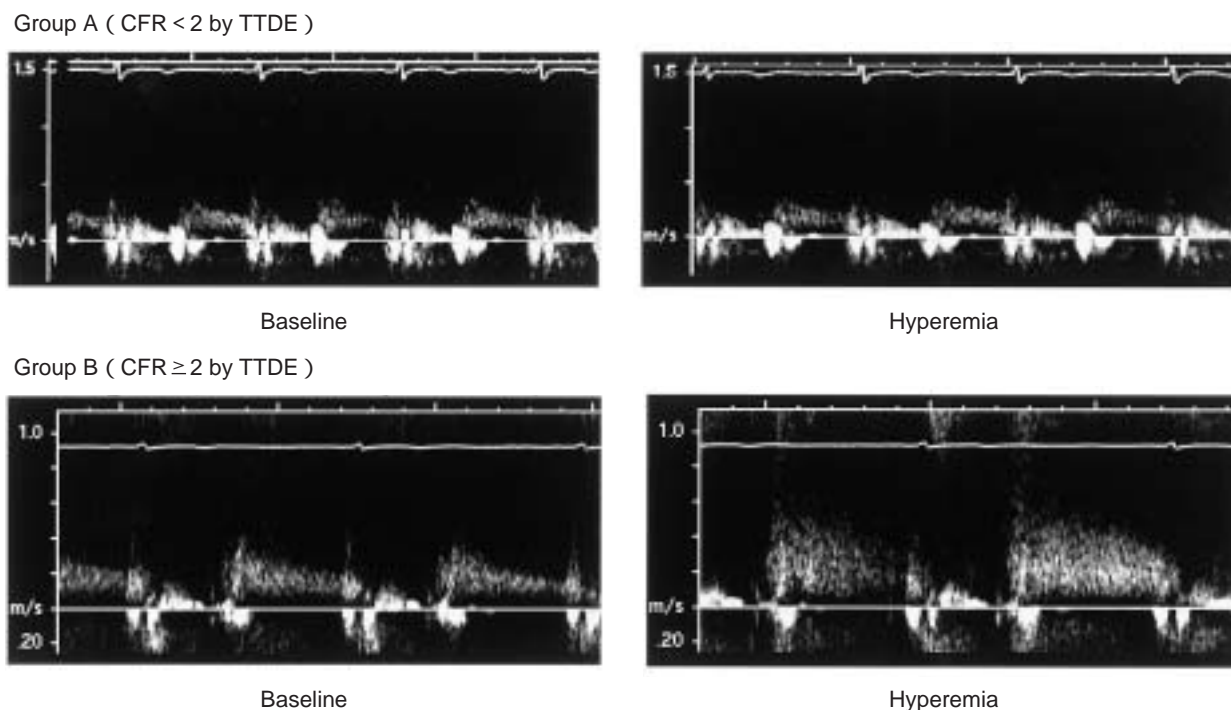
Spectral Doppler signals at the baseline (*left column*) and during hyperemia (*right column*) in a patient of Group A with abnormal myocardial perfusion in the left circumflex artery territories (*upper row*) and in a patient of Group B with normal perfusion in the left circumflex artery territories (*lower row*)
